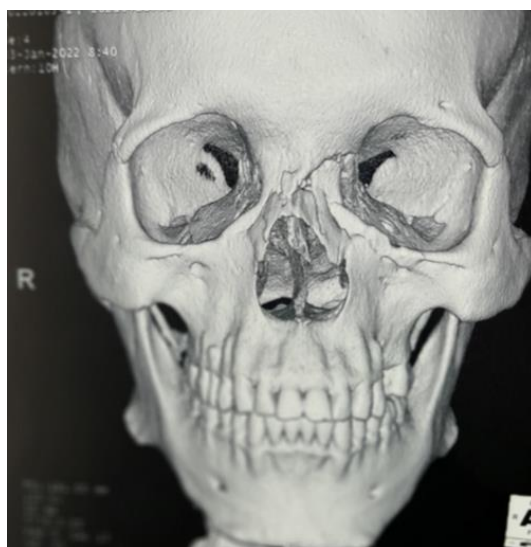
3D CT reconstruction showing complex fracture of the nasal bones
